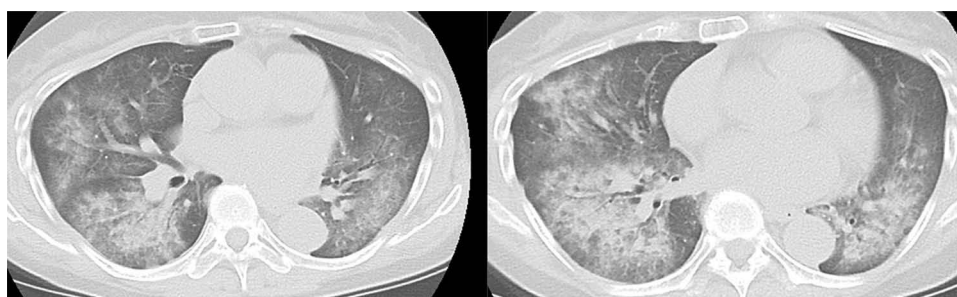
Computed tomography imaging of gefitinib-induced interstitial lung disease in case 3 showing a hypersensitivity pneumonia pattern.
